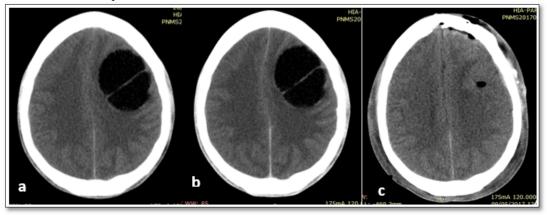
Axial section Brain CT-Scan. a) CT view without contrast agent of the bilobular hydatid cyst in the left frontoparietal region. b) Same cyst after injection of the contrast agent. There is no difference between pictures (a) and (b). Complete and successful removal of the cyst (c).
